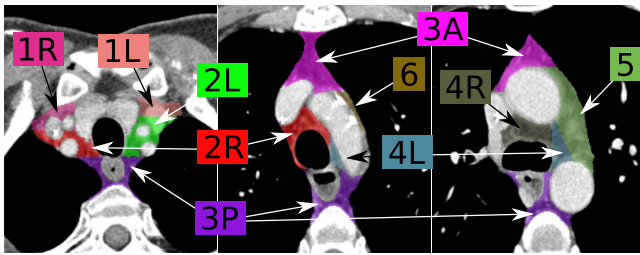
Example of mediastinal lymph node stations delineated on three slices of a thoracic CT.
